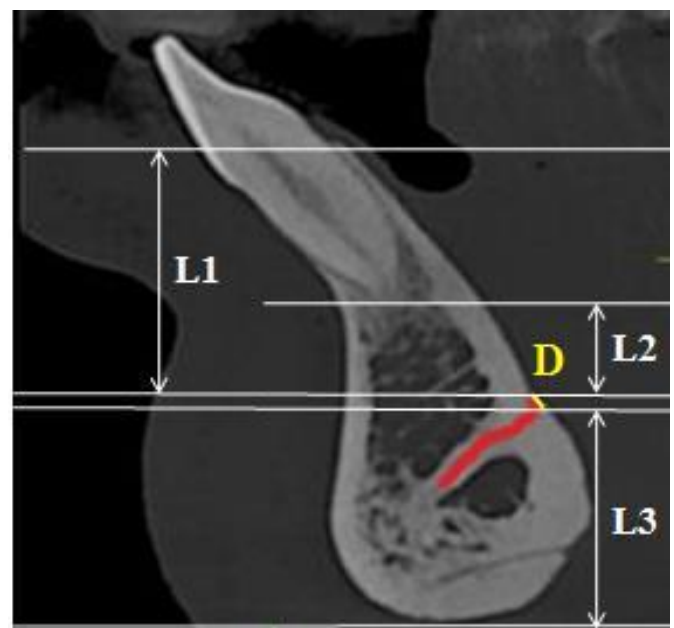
Linear Measurement of lingual foramina on CBCT
